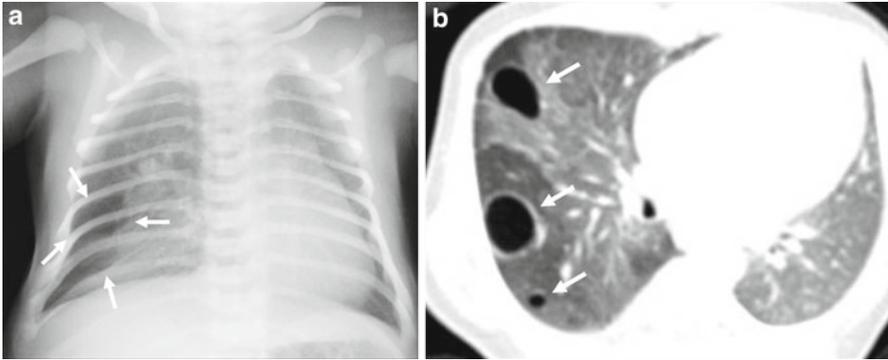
CPAM. (a) Chest radiograph shows right lower lobe multi-cystic lesion (*arrows*). (b) Axial CT image through the lung bases shows multiple well-defined air-filled cysts lesions (*arrows*) involving middle and lower lobes
